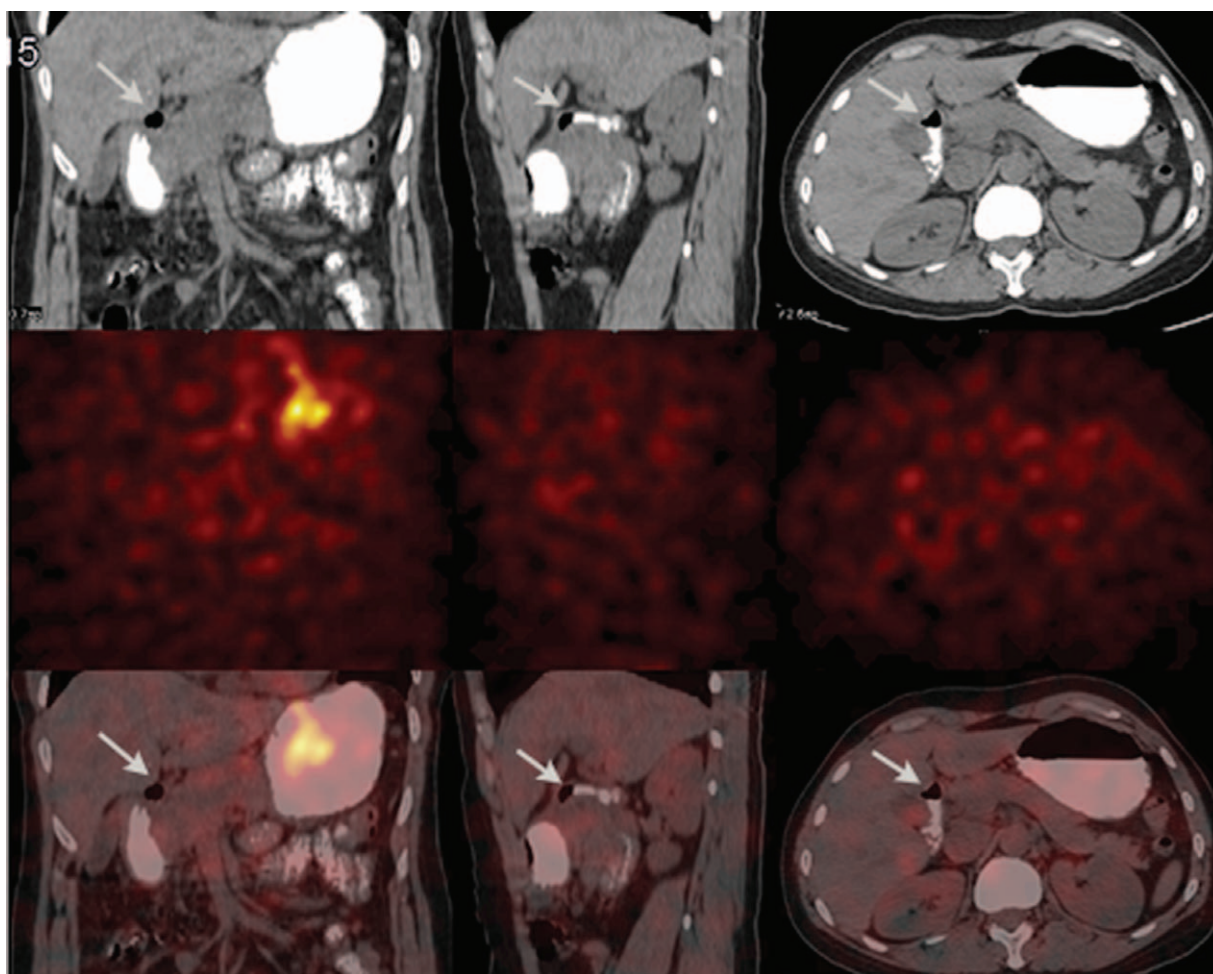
Another SPECT/CT fusion imaging was performed after orally administered 300 ml of 3% iodine contrast agent (top CT, middle SPECT, bottom fusion; left coronal, middle sagittal and right transverse) showed no increased radioactivity in the right upper abdomen (middle SPECT). However, iodine contrast agent filling in the sacculated focus at the descending duodenum was found (top CT and bottom fusion). A cross-channel between the gastrointestinal tract and the diverticulum of descending duodenum was demonstrated. SPECT/CT = single-photon emission computed tomography/computed tomography.
